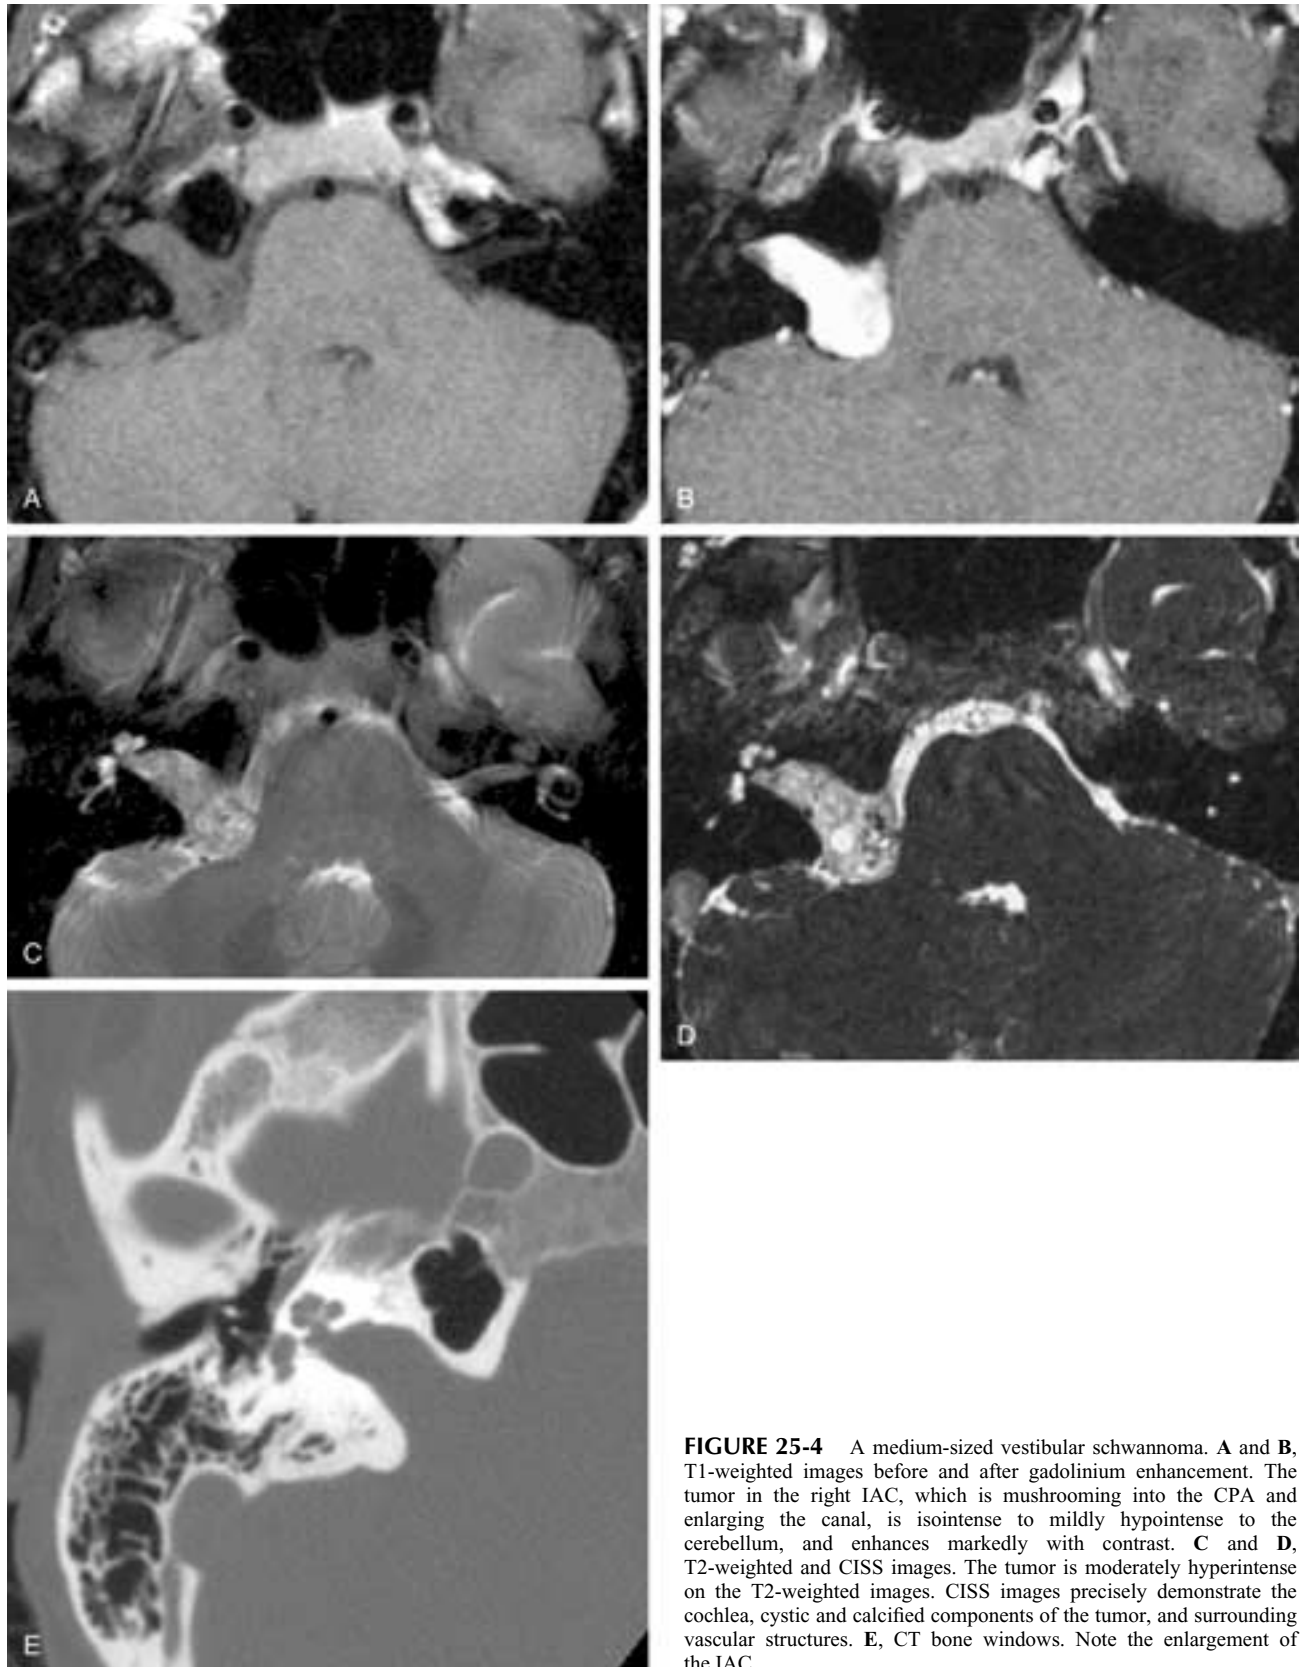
A medium-sized vestibular schwannoma. A and B, T1-weighted images before and after gadolinium enhancement. The tumor in the right IAC, which is mushrooming into the CPA and enlarging the canal, is isointense to mildly hypointense to the cerebellum, and enhances markedly with contrast. C and D, T2-weighted and CISS images. The tumor is moderately hyperintense on the T2-weighted images. CISS images precisely demonstrate the cochlea, cystic and calcified components of the tumor, and surrounding vascular structures. E, CT bone windows. Note the enlargement of the IAC.
